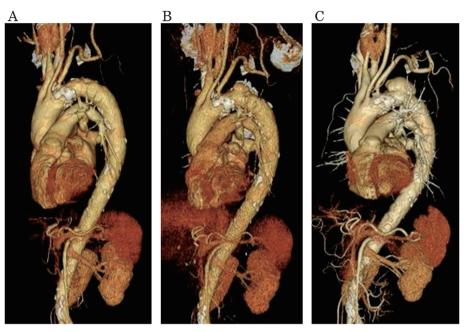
A, B, and C show three-dimensional computed tomography (CT) reconstruction images obtained 8 months before admission, at admission, and before surgery, respectively. A saccular aneurysm of the distal aortic arch with a maximum diameter of 38 mm was forming on the cranial side at admission (B). Repeated CT after 2 weeks demonstrated an enlargement of the aneurysm to 44 mm in diameter (C).
